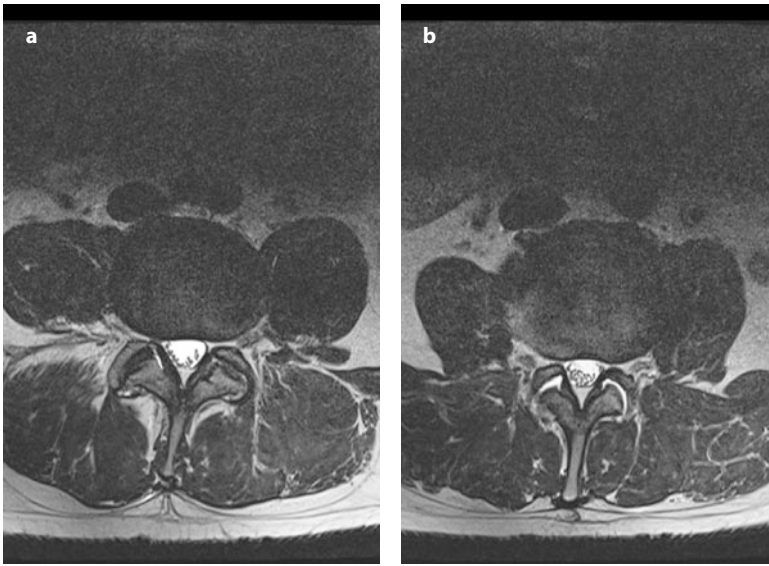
Axial T2-weighted image at the level of the L4–L5 intervertebral disk space (a) demonstrating a hypertrophic facet joint with wrap-around osteophytes and hypertrophic ligamentum flavum bilaterally. This results in slight narrowing of the central spinal canal and lateral recesses. Axial T2-weighted image at the level of the L3–L4 intervertebral disk space showing increased fluid in the facet joint bilaterally (b)
